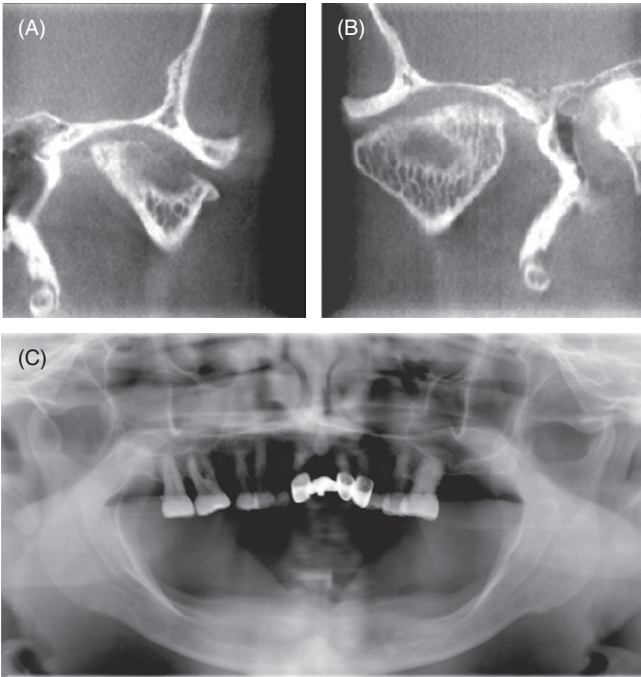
Osteoarthritis affecting the temporomandibular joint (TMJ). Computed tomographic scan of left TMJ (A) and right TMJ (B); panoramic radiograph (C) of the same patient, showing erosive and irregular cortical outline of the surface of the condylar head characteristic of degenerative changes secondary to osteoarthritis in both TMJs.
